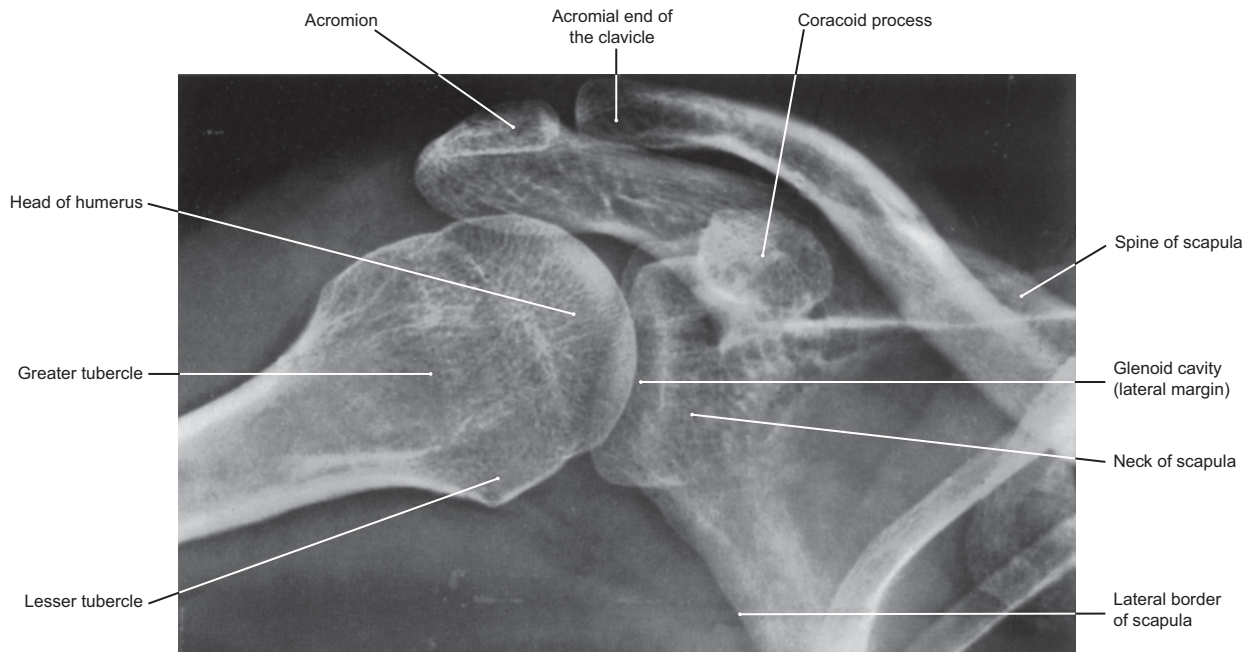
Radiograph of the Right Shoulder Joint
